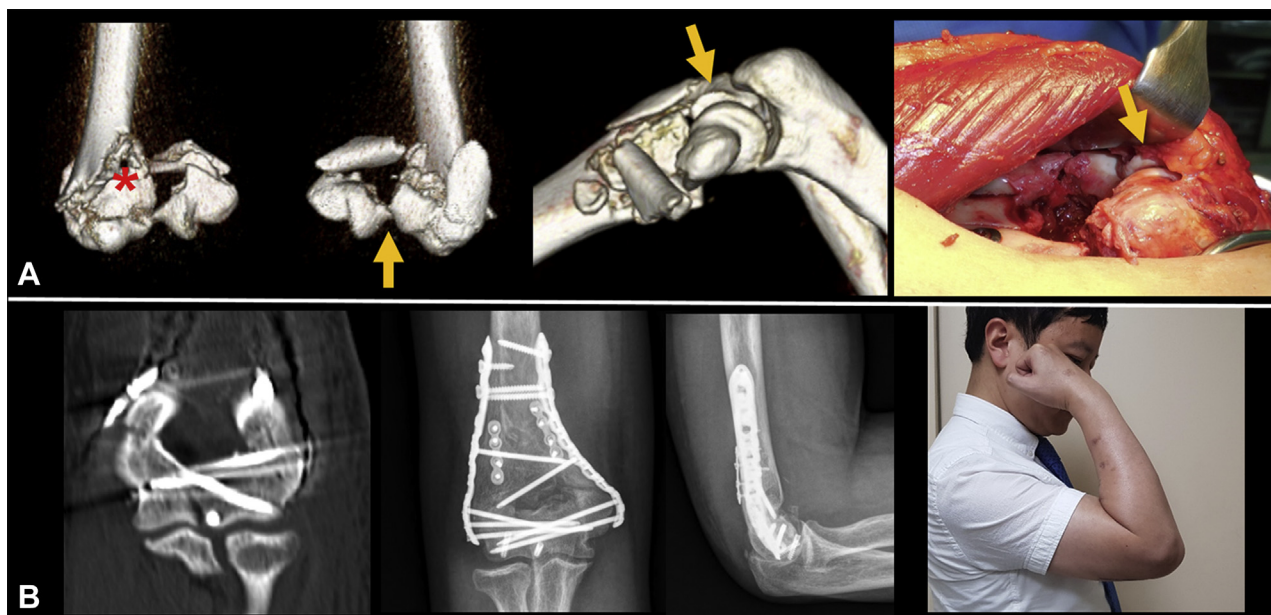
A 48-year-old male patient sustained an AO/OTA type C3 articular fracture of the distal humerus. (A) Three-dimensional computed tomography demonstrated that the articular fragment had a free coronal capitello-trochlear fragment (*) and the main articular fracture line was located in zone 2. Its visualization was hindered by the olecranon process (*arrows*). (B) After osteosynthesis through the expanded paratricipital approach, postoperative computed tomography showed a 1.7-mm articular gap, which was classified as a nonanatomic reduction. However, 1.5-year follow-up radiographs demonstrate complete fracture healing without any complications. Full recovery of final range of motion was observed.
